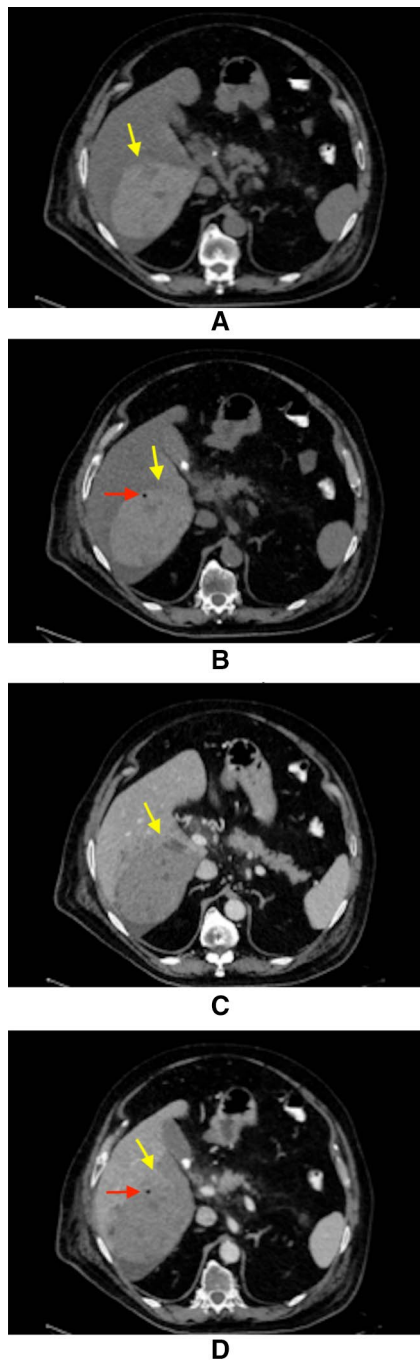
Different CT sections with and without contrast dye. a CT scan showing the presence of hepatic hematoma (yellow arrow) without contrast dye, b CT scan showing the presence of hepatic hematoma (yellow arrow) and intra-hematoma air (red arrow) without contrast dye, c CT scan showing the presence of hepatic hematoma (yellow arrow) with contrast dye, d CT scan showing the presence of hepatic hematoma (yellow arrow) and intra-hematoma air (red arrow) with contrast dye
